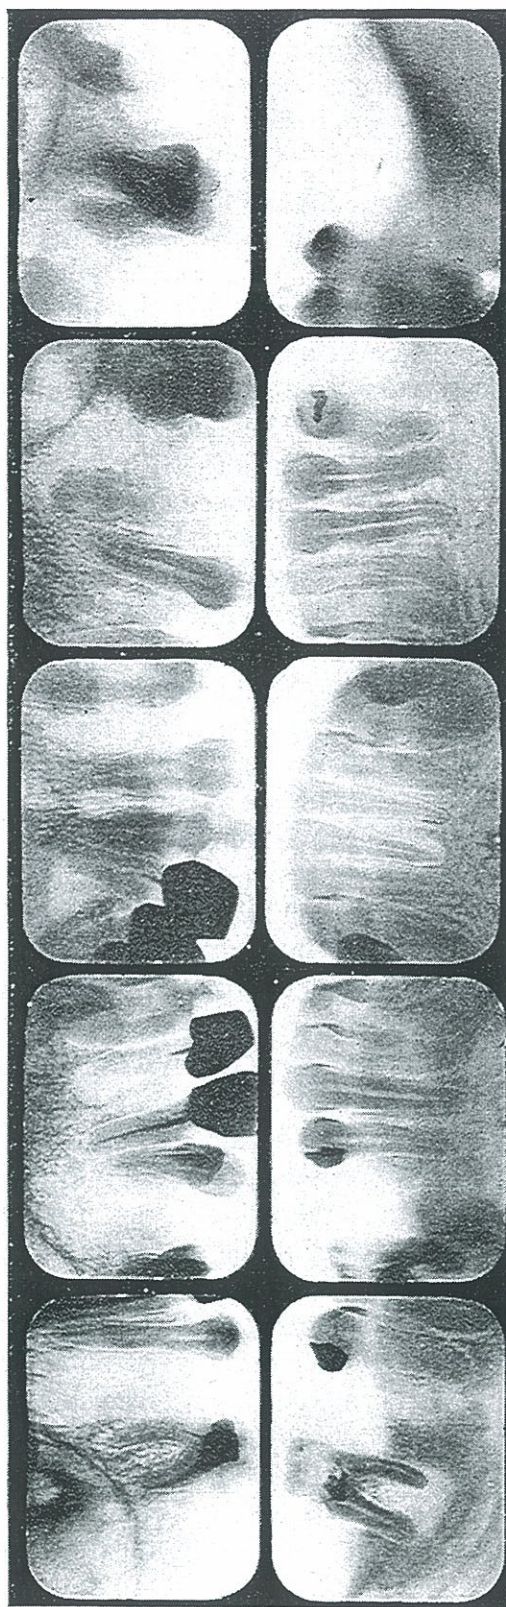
ROENTGENOGRAPHIC APPEARANCE OF THE TEETH OF THE PATIENT, CASE NO. 1269. THIS WOMAN IS A HELPLESS BEDRIDDEN CRIPPLE AND SEVERE SUFFERER, PROBABLY LARGELY BROUGHT ON BY THE OVERLOAD OF SIX PREGNANCIES IN SEVEN YEARS TOGETHER WITH DENTAL INFECTIONS.
